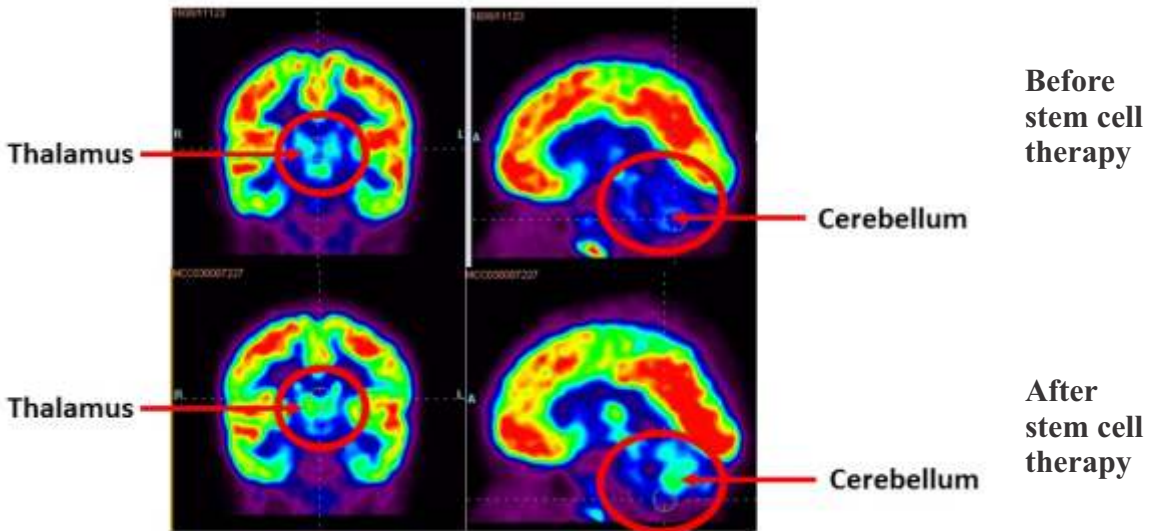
Comparative PET CT scans of an autism patient performed before and after stem cell therapy. Significant improvement was observed in medial temporal, thalamus and cerebellum.
